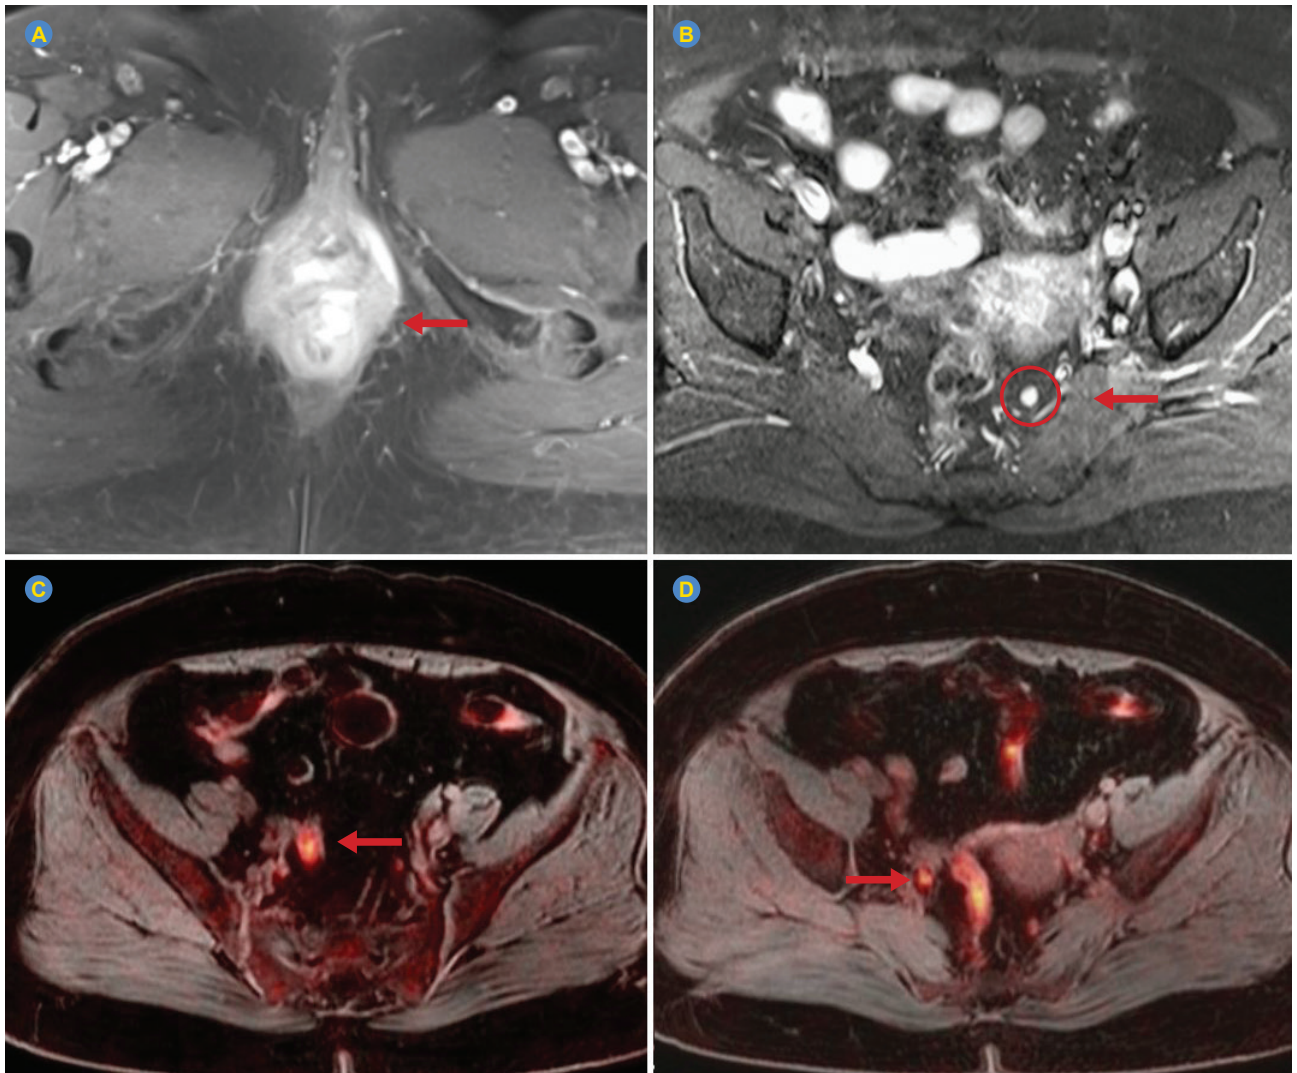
Pelvic magnetic resonance imaging with T1 mapping: defect extending into the intersphincteric space (A). Perirectal lymphadenopathy (B). Positron emission tomography/magnetic resonance imaging: (C) and (D) pathological 18F-FDG uptake in the left presacral and left perirectal lymph nodes.
